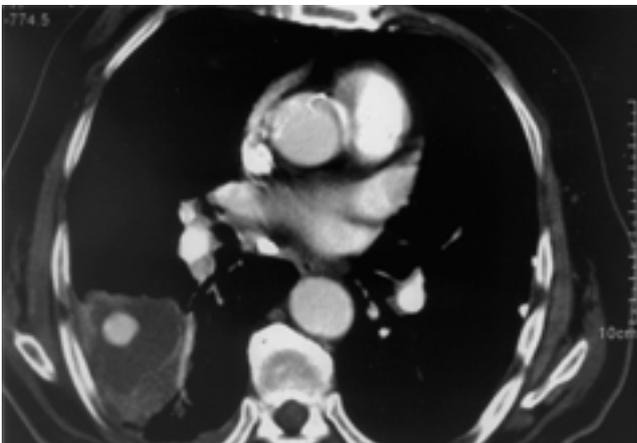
Axial CT image shows a round, well-enhancing lesion within the low attenuated consolidation in the right lower lobe.
